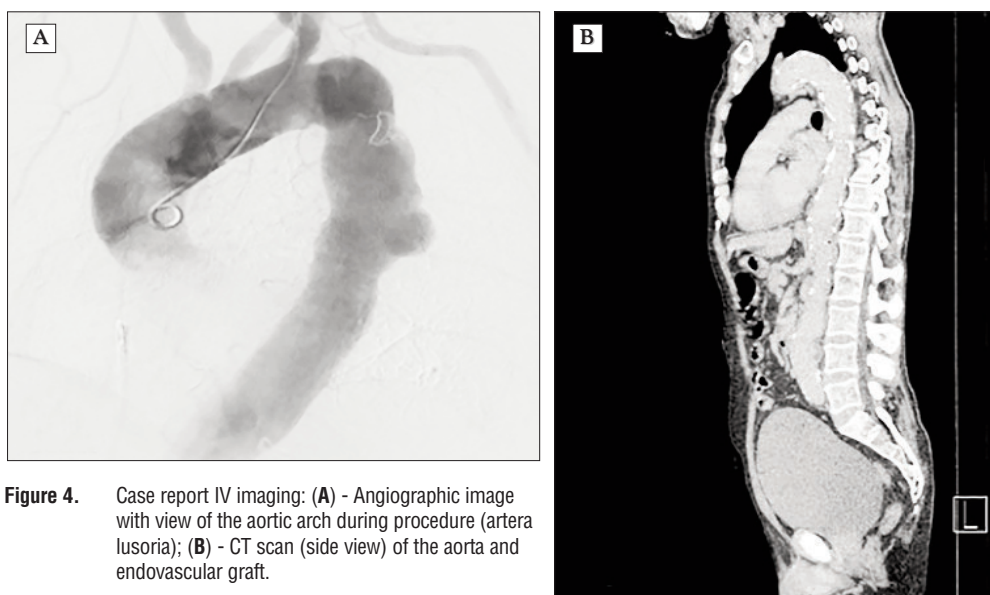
Case report IV imaging: (A) - Angiographic image with view of the aortic arch during procedure (arteriolumbaria); (B) - CT scan (side view) of the aorta and endovascular graft.
